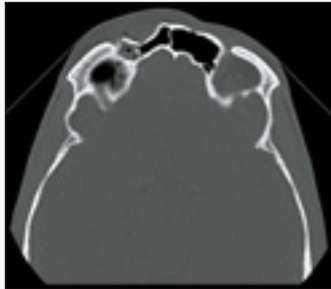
Axial CT image of patient with right supraorbital rim fracture and concomitant fracture of the anterior table of the frontal sinus.
